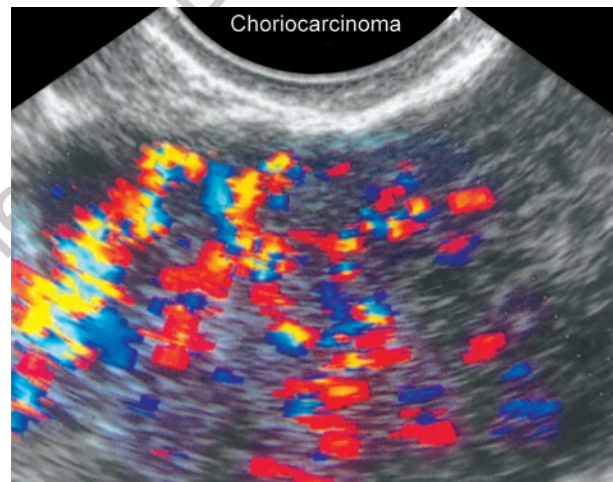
Transvaginal color Doppler scan of choriocarcinoma showing randomly dispersed vessels.
